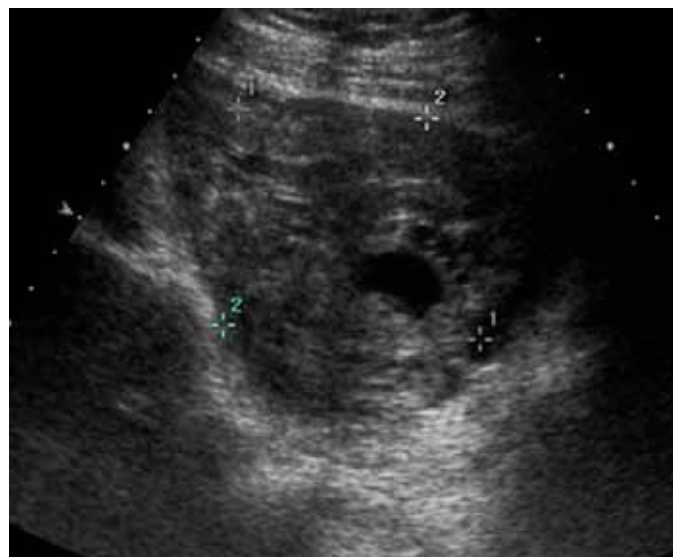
Transvaginal ultrasound of left adnexa. Adjacent to the left ovary there is a 8.9x5.6x6 cm complex mass which contains a 2.2–2.2 mm anechoic structure.
